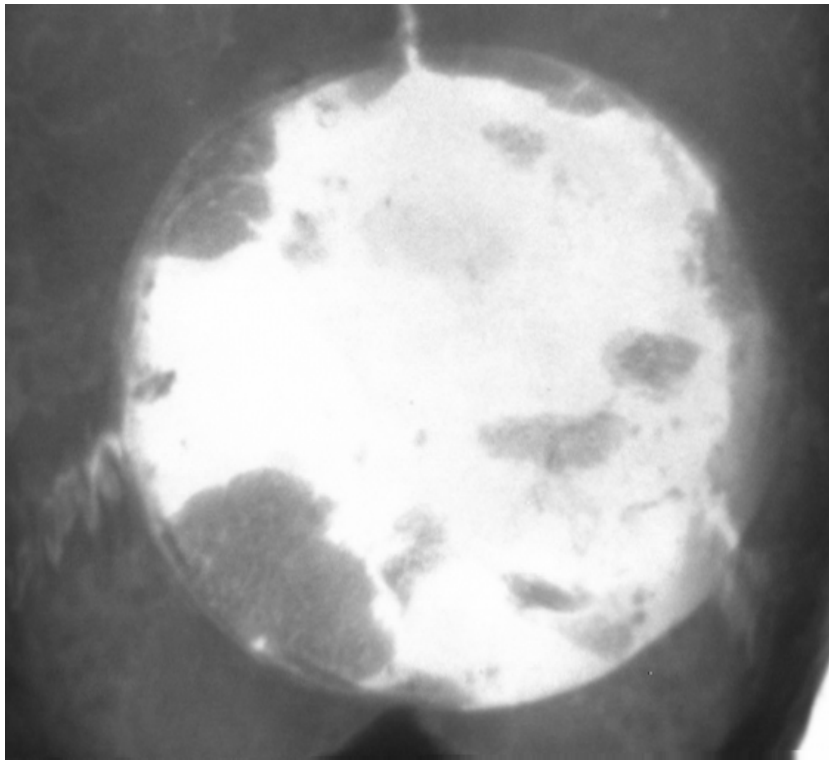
Micro CT image of DuraGen® + saline at 4 weeks
